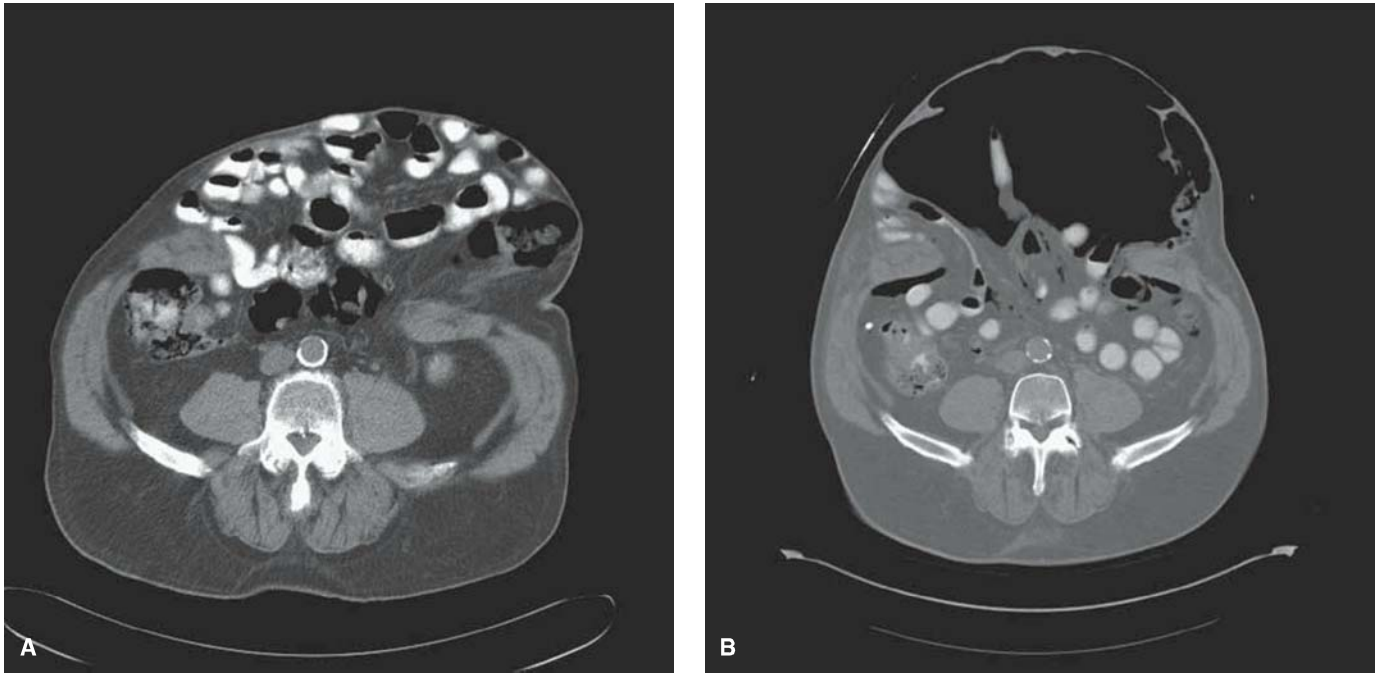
A: Preoperative CT scan demonstrating herniated contents with loss of domain. B: CT in same patient after progressive preoperative pneumoperitoneum demonstrates that bowel contents have fallen below the level of the hernia orifice.
